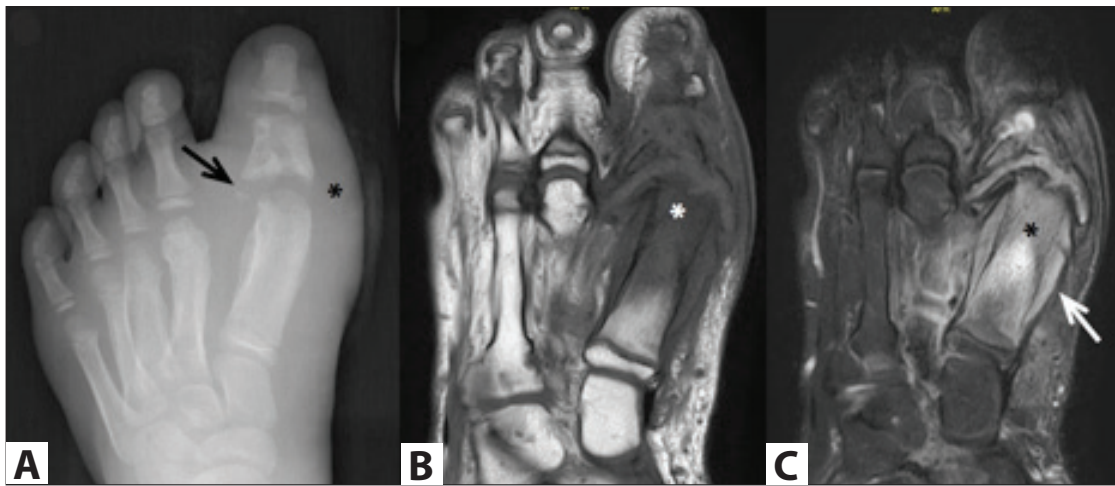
Anteroposterior radiograph of the right foot (A) enlargement of the first metatarsophalangeal and interphalangeal joints, irregularity, and fragmentation of the articular surfaces (black arrow), solid periosteal reaction and sclerosis in the first to third metatarsals, sclerosis in the proximal phalanx with lytic areas and soft tissue swelling around the joint (asterisk). On long axis T1-weighted pre-contrast (B) and fat-suppressed T2-weighted (C) images, bone marrow intensity changes (asterixes) consistent with osteomyelitis around the first metatarsophalangeal joint and periosteal reaction surrounding the first metatarsal with destruction on the joint surfaces (white arrow) are observed.
